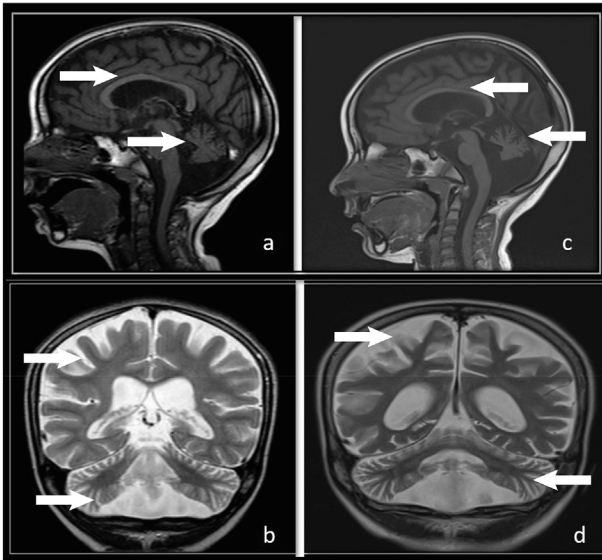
Patient 1 – T1-weighted sagittal sections (a, c) and T2-weighted coronal sections (b, d) from two different MRI scans. Sections a and b were taken 1 year after the onset of symptoms. Sections c and d were taken 2 years after the onset of symptoms. This figure clearly demonstrates progression of cerebral (b, d) and cerebellar (a, b, c, d) atrophy and thinning of the corpus callosum (a, c).
